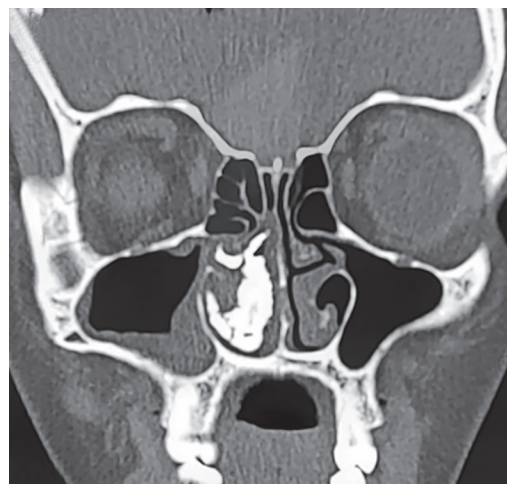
Computed tomography revealed linear cranial ramifications abutting and insinuating the middle turbinate
